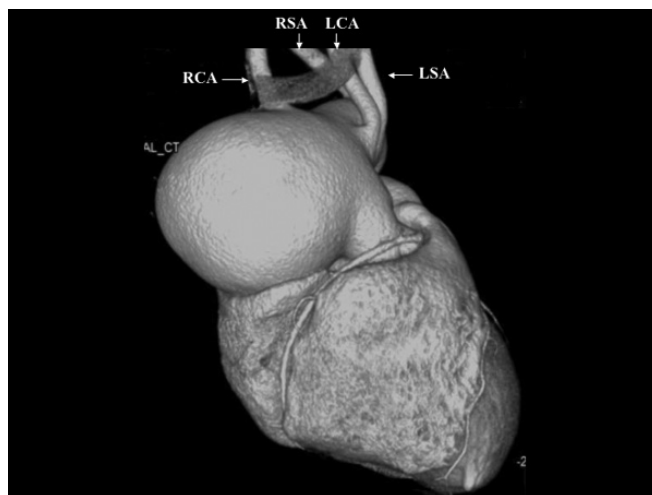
Computed tomography scan of the patient shows an aneurysm of the ascending aorta extending to the aortic arch. An aberrant right subclavian artery arises from the aorta and runs behind the esophagus.
